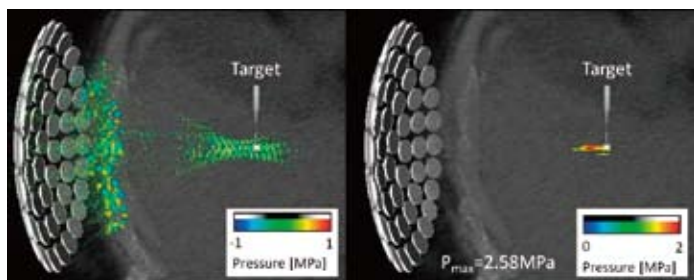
Condition of ultrasound transmission (left) and the position of focal point (right) when the HIFU system is not controlled
